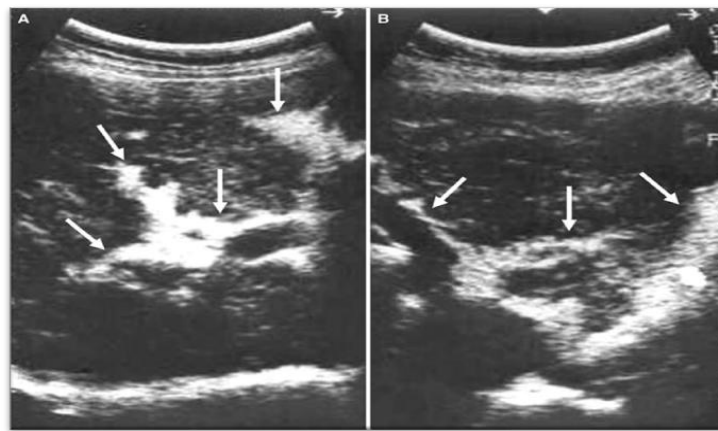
Ultrasound of *S. mansoni* infected 40-year-old man. Sonogram of the right (A) and left hepatic lobe (B) shows hyper-echoic, thick, fibrous bands along the portal vein branches (arrows) (Image courtesy: Manzella *et al.*, 2008).
